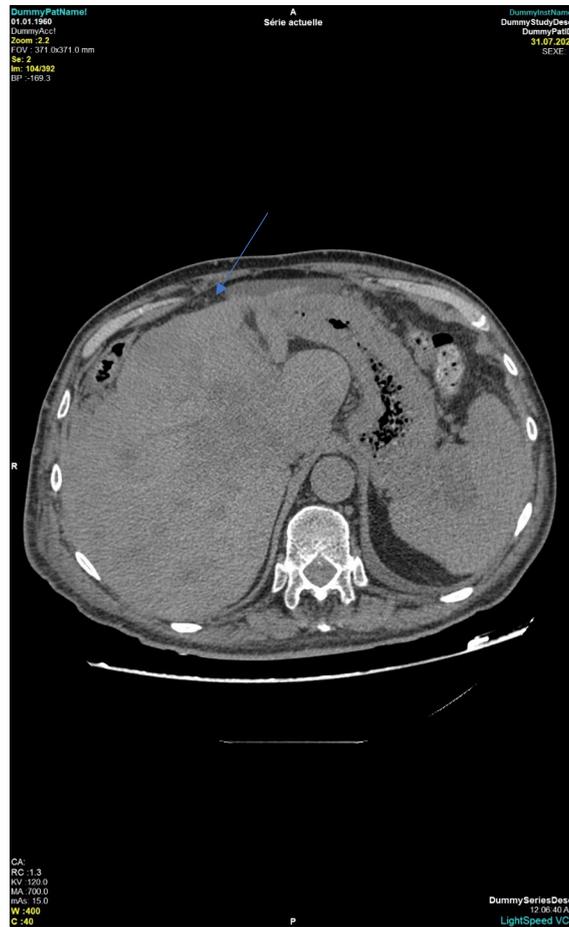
CT scan showing diffuse hypodense metastatic nodules in the liver and the spleen. Micronodular aspect of the peritoneum compatible with peritoneal carcinomatosis (blue arrow).
